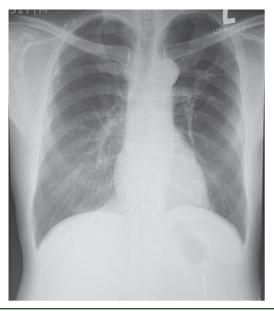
Chest X-ray of case 2 (post-treatment of tuberculosis) showed improvement of left upper lung infiltration.
